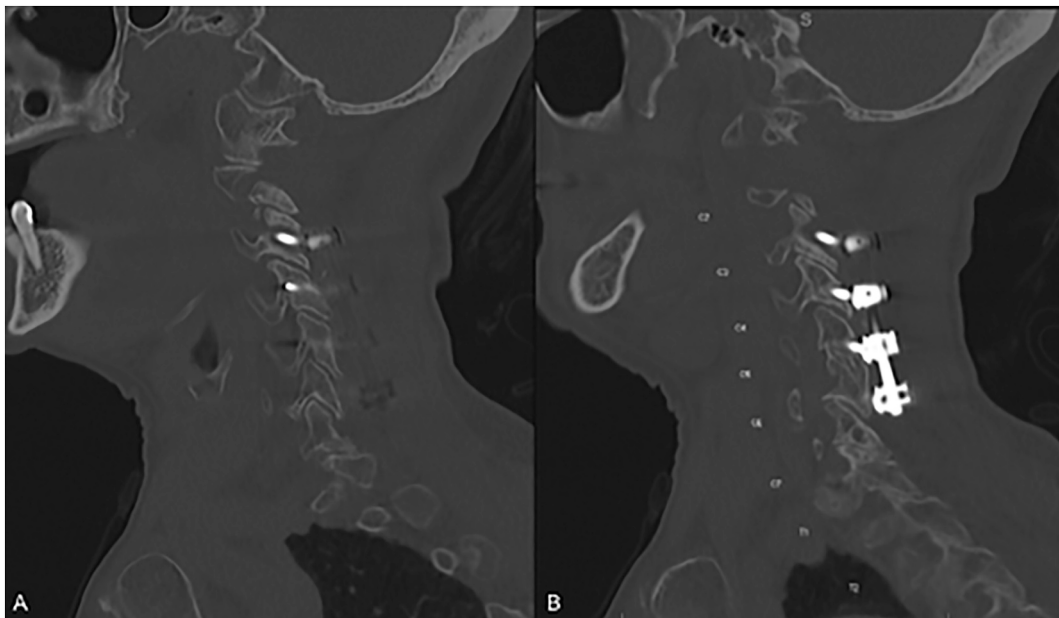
A/B: Pre-operative CT scan showing lucency in vicinity of C3 lateral mass screws.
